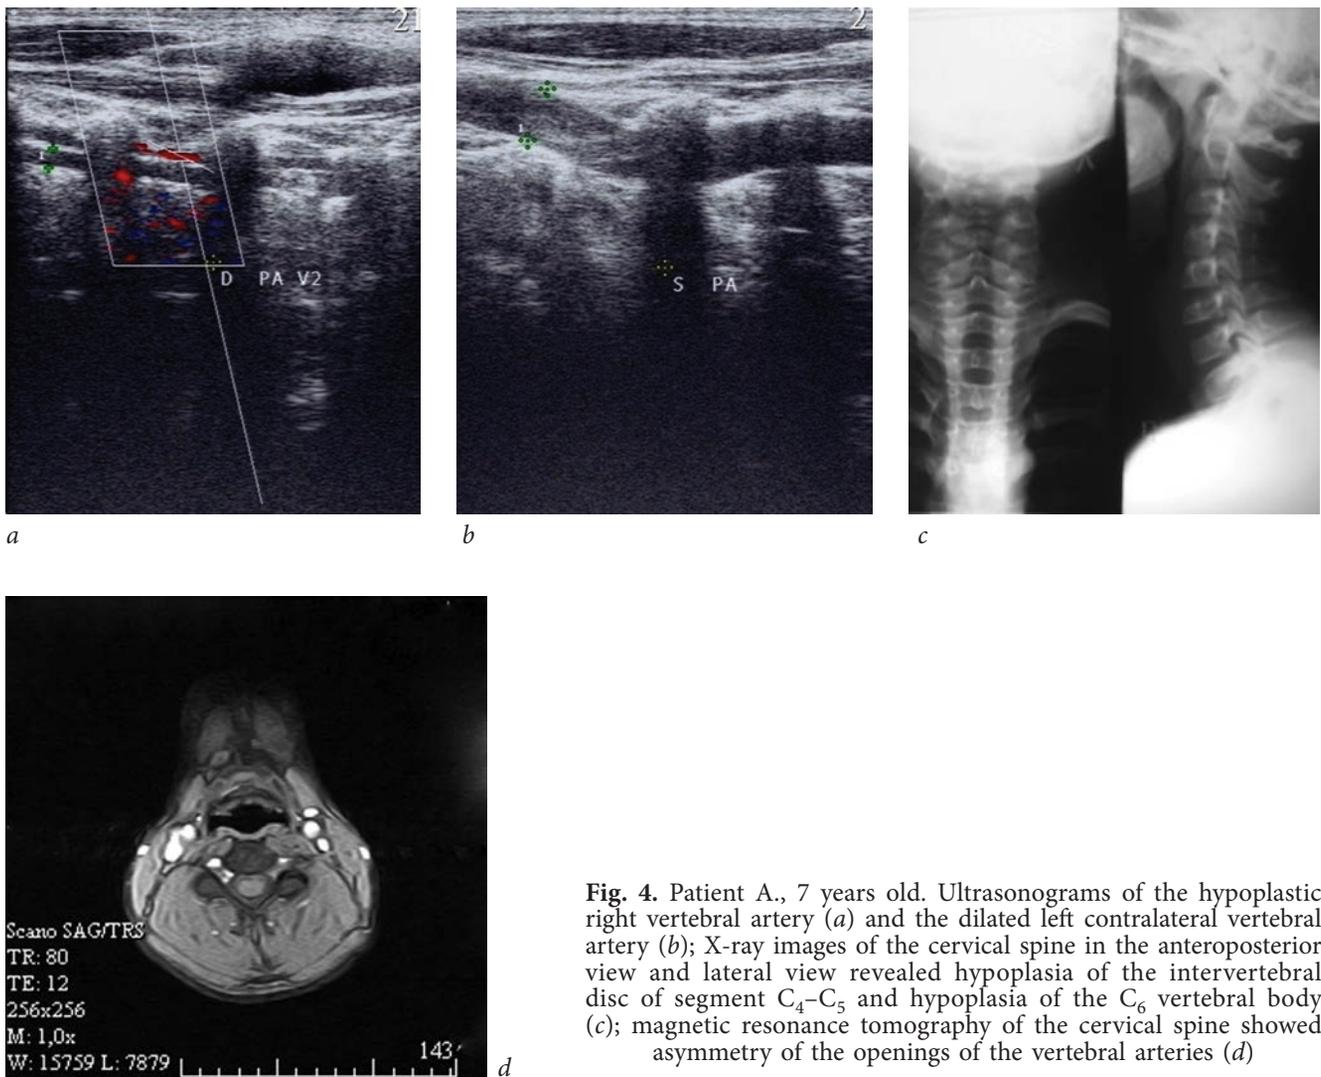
Patient A., 7 years old. Ultrasonograms of the hypoplastic right vertebral artery (a) and the dilated left contralateral vertebral artery (b); X-ray images of the cervical spine in the anteroposterior view and lateral view revealed hypoplasia of the intervertebral disc of segment C₄-C₅ and hypoplasia of the C₆ vertebral body (c); magnetic resonance tomography of the cervical spine showed asymmetry of the openings of the vertebral arteries (d)
